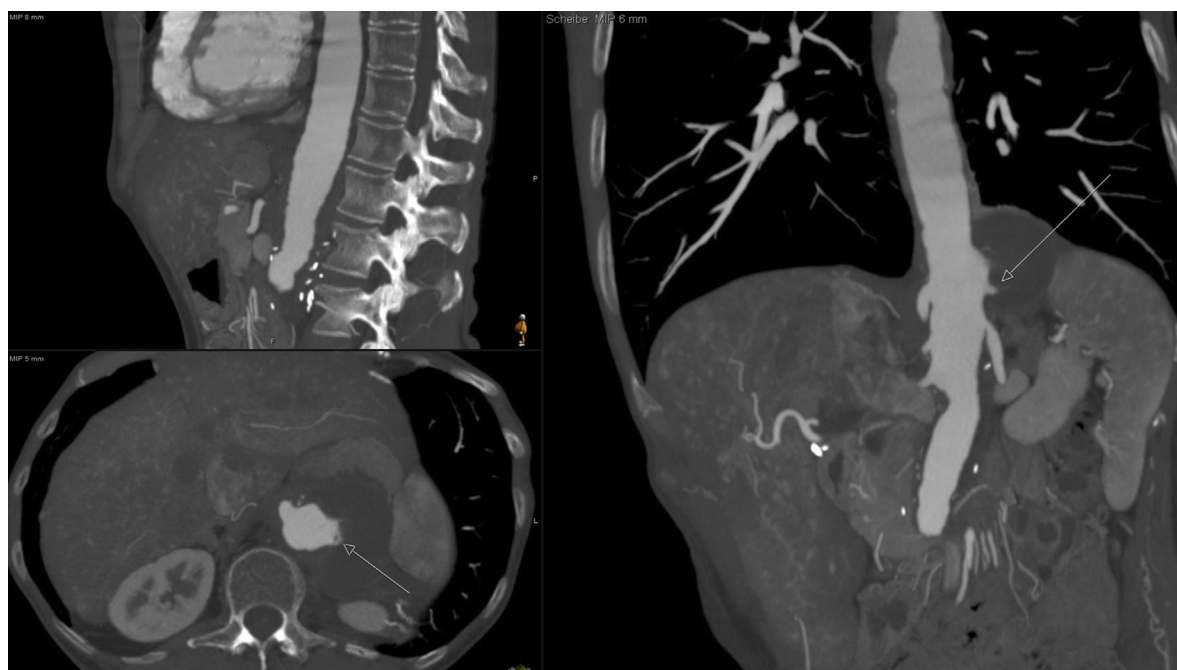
Multiplanar reconstruction of the coronal, axial, and sagittal planes of the preoperative computed tomography angiogram. The *arrows* mark the rupture site.
